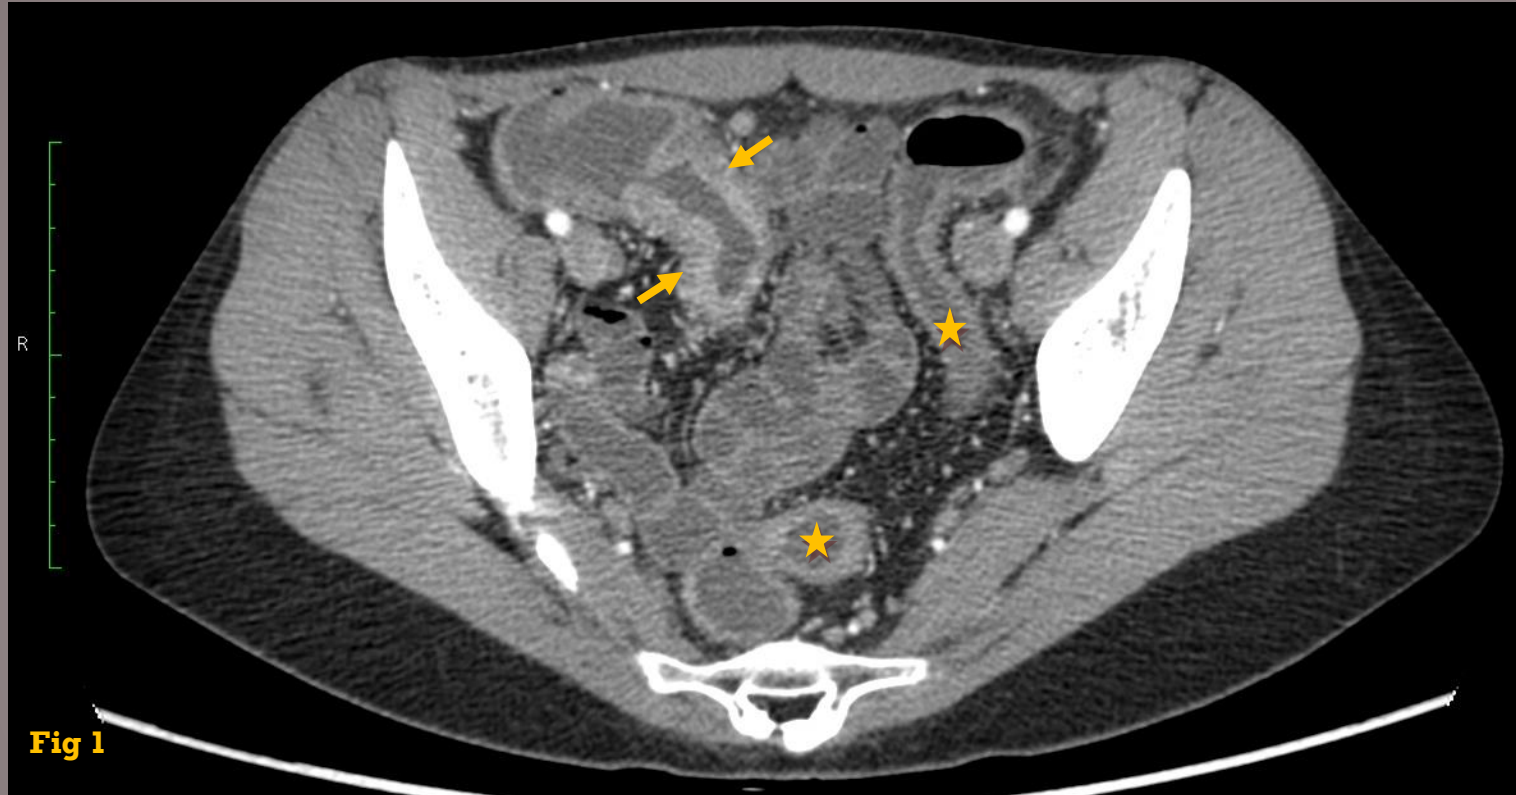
Axial CT enterographic section shows continuous involvement of the large bowel (stars) and backwash ileitis, with a gray pattern of attenuation (arrows).
